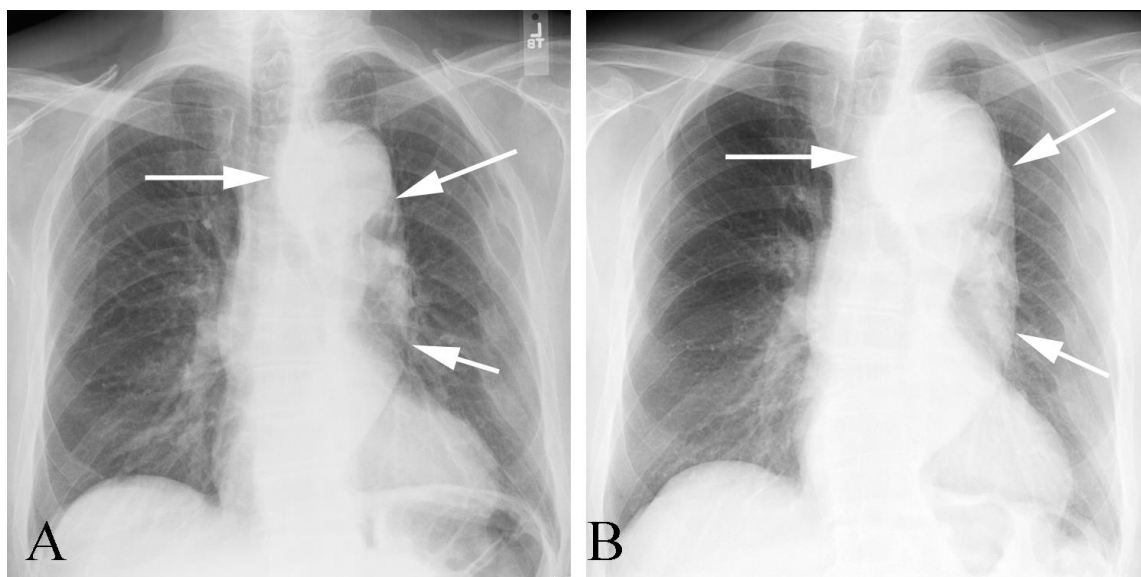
Enlarging thoracic aortic aneurysm in an 84 year old man with chest pressure. A. PA chest x-ray shows a dilated, tortuous aortic aneurysm (arrows). B. PA chest x-ray taken 18 months later (when the patient had a sensation of increasing chest pressure) shows that the aneurysm is larger (arrows).
